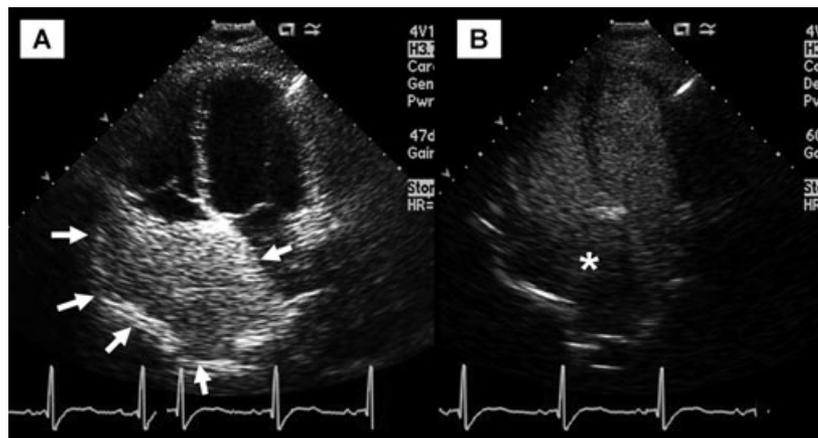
Transthoracic Echocardiogram A. Noncontrast transthoracic echocardiogram in apical four-chamber view showing a homogenous mass filling the entire right atrium (arrows). B. Transthoracic echocardiogram showing brisk opacification of the right atrial mass (asterisk) after intravenous perflutren lipid microsphere contrast (Definity) injection.
